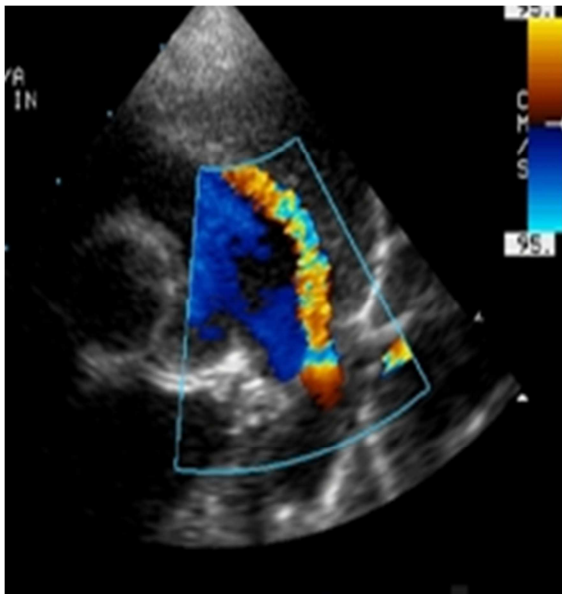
Patent ductus arteriosus (PDA) in Transthoracic echocardiography
